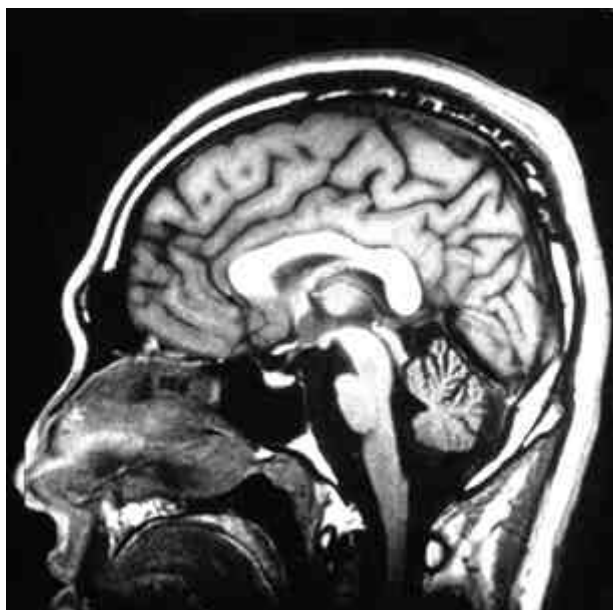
T1-weighted sagittal MR image of a patient. Cerebellar vermis is atrophic and the fourth ventricle is enlarged.
